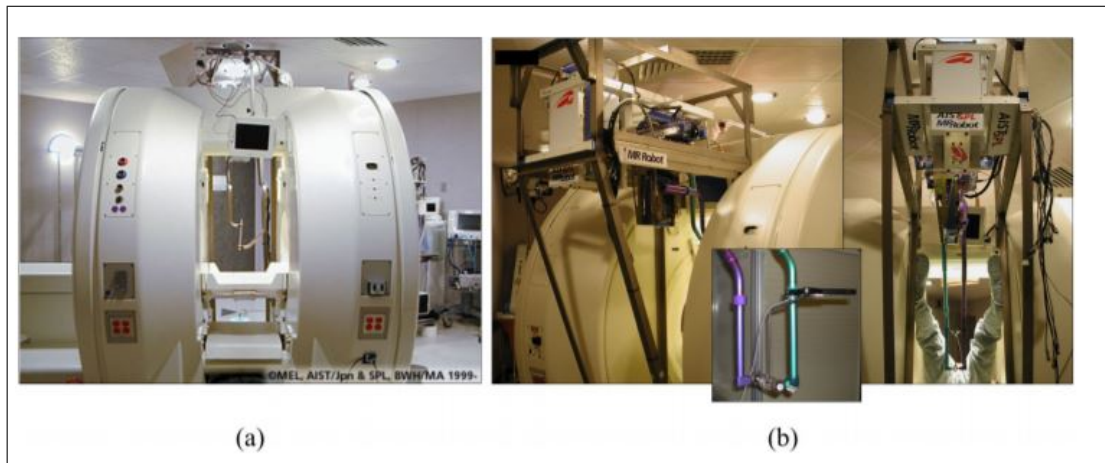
a) Open-MRI scanner b) 5-DOF MR-compatible robot which equipped with an optical tracking (inset) [4]
